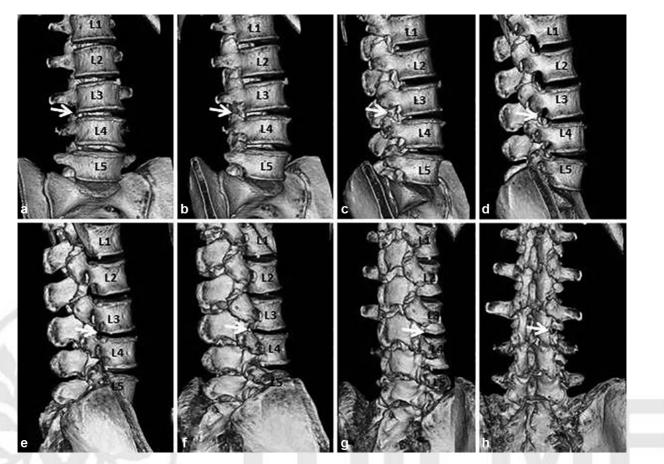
Postoperative three-dimensional computed tomography (3D CT) images of L3–L4 right-side far-lateral lumbar disk herniation (FLDH) (a–h) Turn through anterior to posterior.
